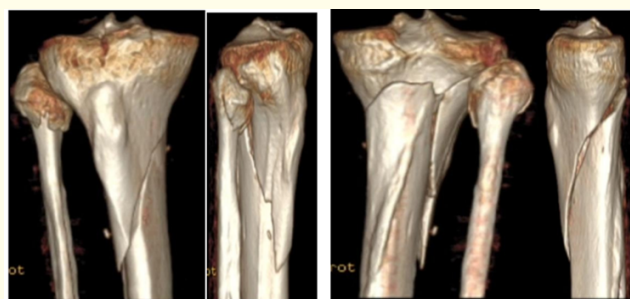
CT scan images.
